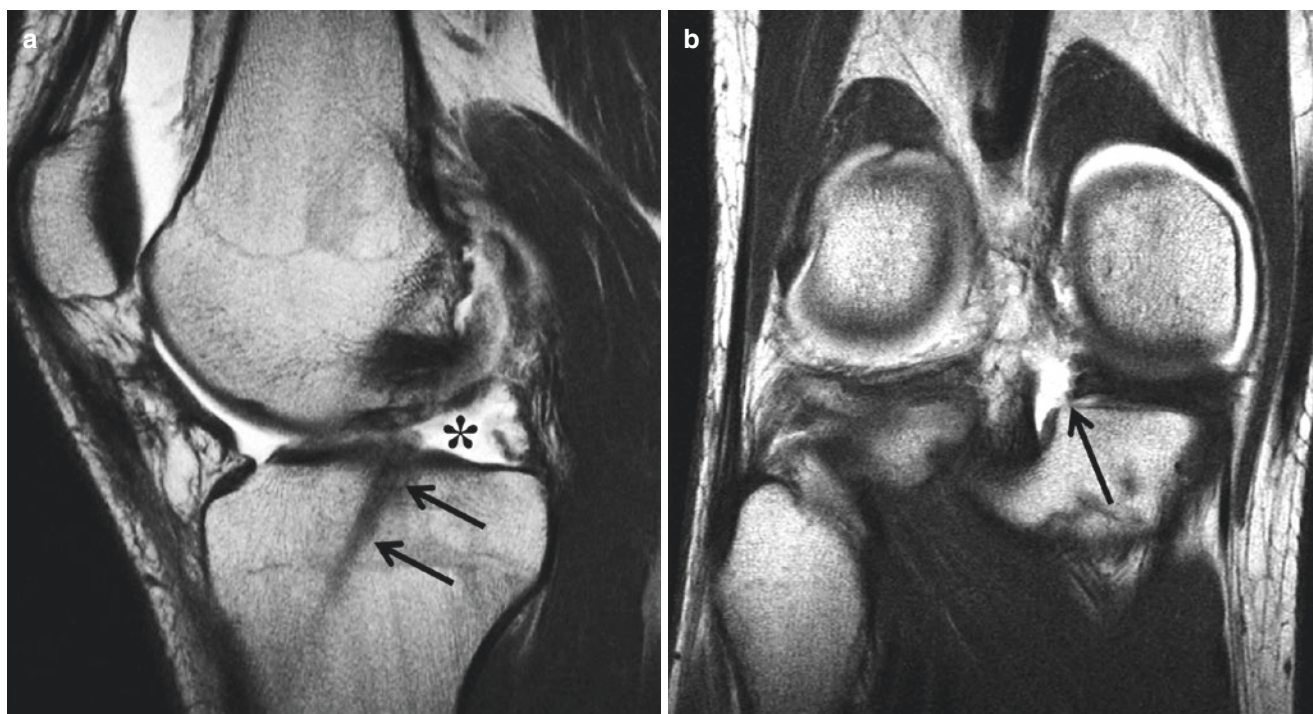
Failed posterior medial meniscal root repair in a 23-year-old man. (a) Sagittal T2-weighted image shows trans tibial tunnel (arrows) drilled for suture passage without attached meniscal tissue (asterisk).
